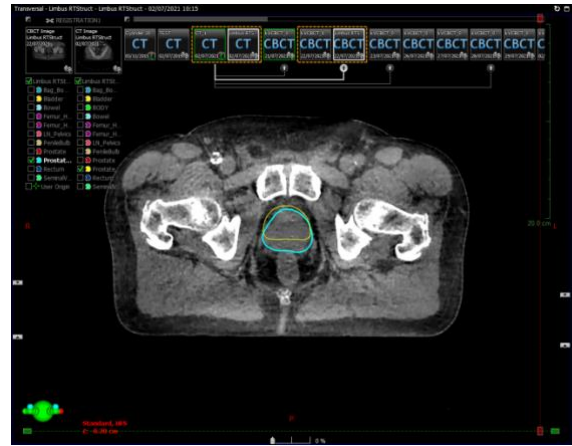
Axial slice of CBCT. Note less distended rectum. Prostate contoured on planning CT in yellow. Prostate contoured on CBCT in turquoise.
